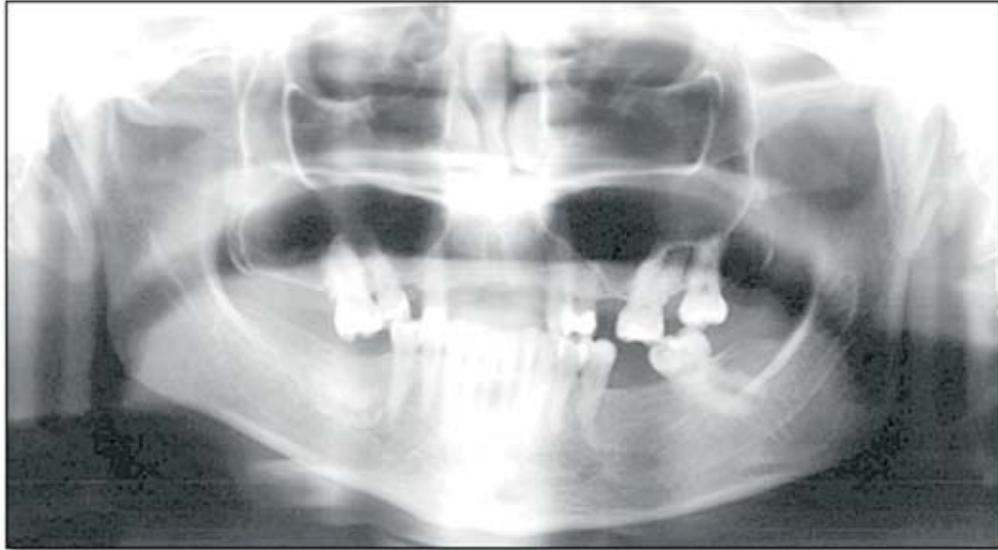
Initial panoramic radiograph showing the bulky shape of the left condyle and a marked deformity of the left mandibular body, angle, and ramus.
